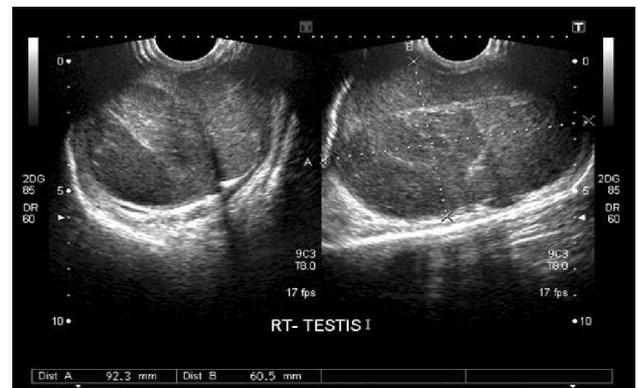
Ultrasound showing enlarged right testis, the entire parenchyma replaced by multiple hypoechoic mass lesions.
